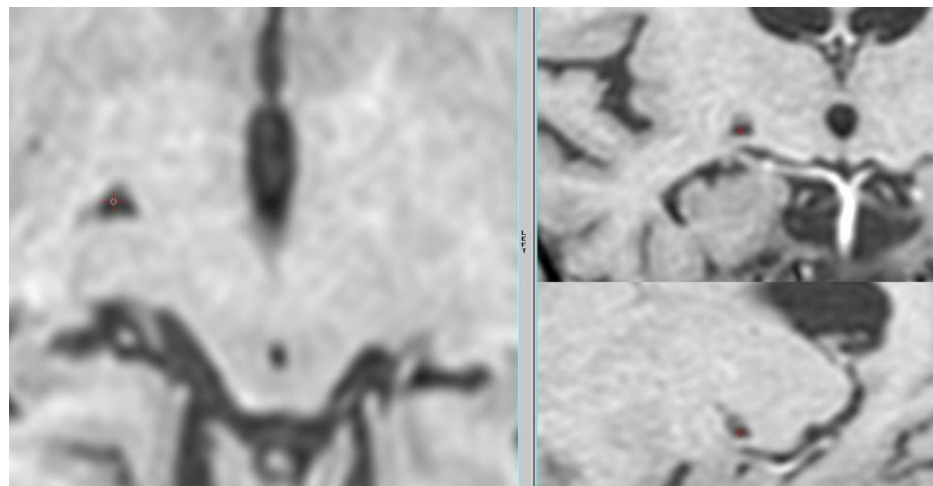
Two years follow up MRI T1: Hypointense right Gpi lesioning (red cross). a. axial -4 level, b. coronal and c. sagittal plane
